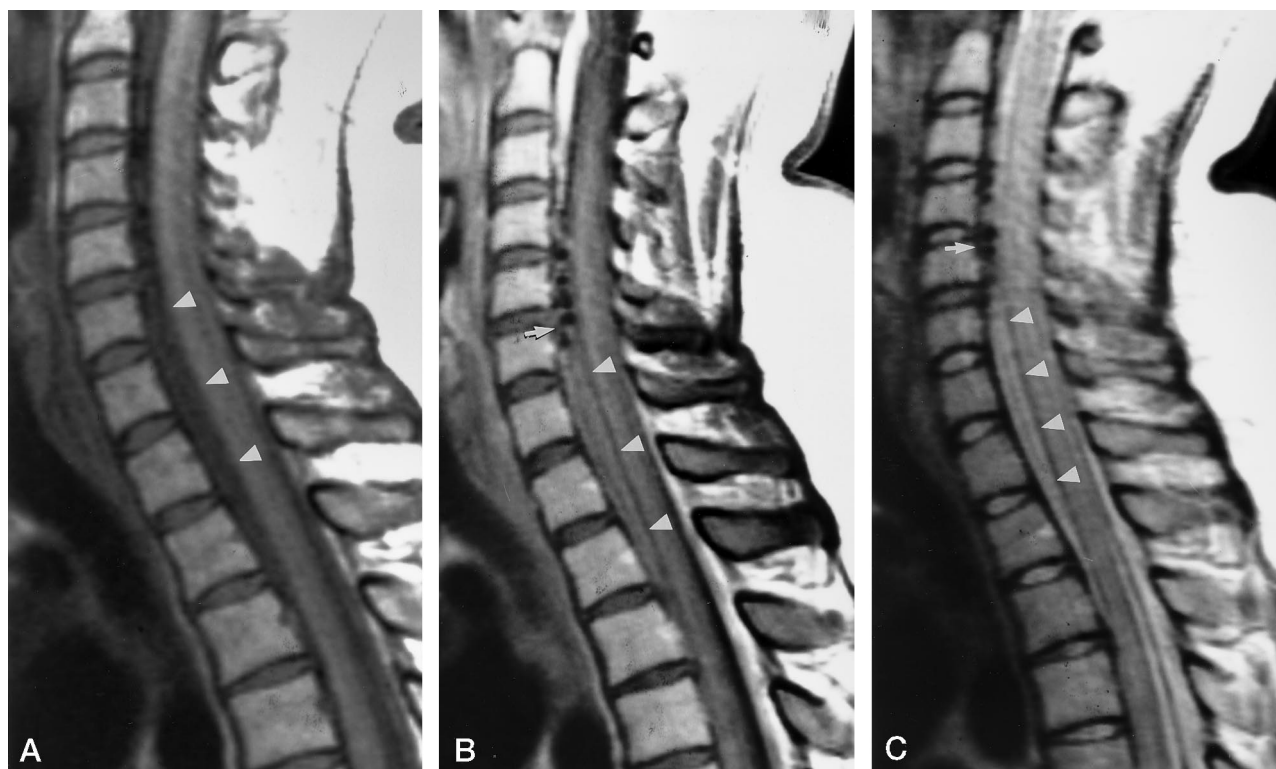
Case 2: 27-year-old woman with 2-week history of positional headaches associated with horizontal diplopia. Sagittal T1-weighted (600/12/5) (A), contrast-enhanced T1-weighted (600/12/5) (B), and proton density-weighted (3500/22/2) (C) images of the cervicothoracic spine show a small ventral extradural fluid collection (arrowheads) that is isointense with CSF. Note the mild enhancement of the fluid collection on the contrast-enhanced image (B). In addition, prominent flow voids are evident in the ventral epidural space at C-3 to C-5 (arrow, B and C) adjacent to the fluid collection, caused by prominent epidural veins. The intracranial dural enhancement continues into the upper cervical spine.
